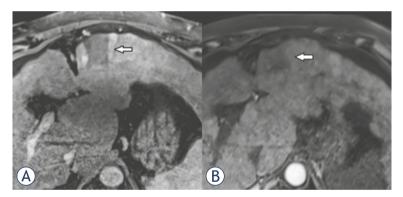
A 66- year-old male with hepatocellular carcinoma (HCC). Control MRI of liver 2 months (A) and 6 months (B) after procedure showing an unenhancing area of ablation – a complete response according to mRECIST criteria.
